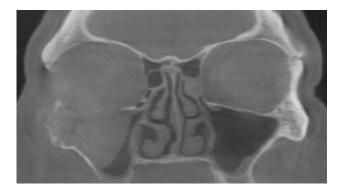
Coronal CT: periorbital tissue mass invading the orbital floor, the malar bone, and the right maxillary sinus.
